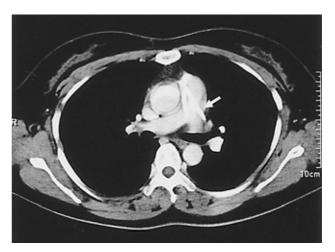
Computed tomography of the chest confirmed the catheter artifact in the pulmonary artery (arrow).
